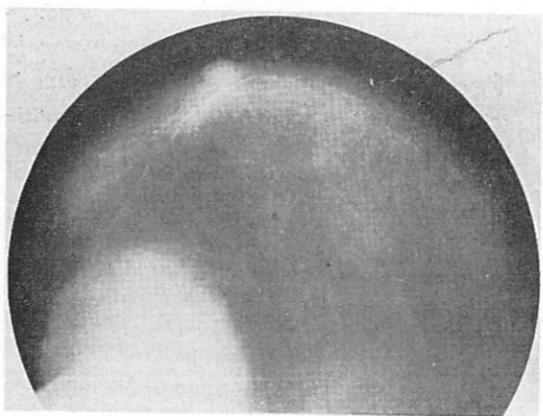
Rounded shadow, opaque to the roentgen rays, with an encapsulated appearance. Tuberculous abscess.
